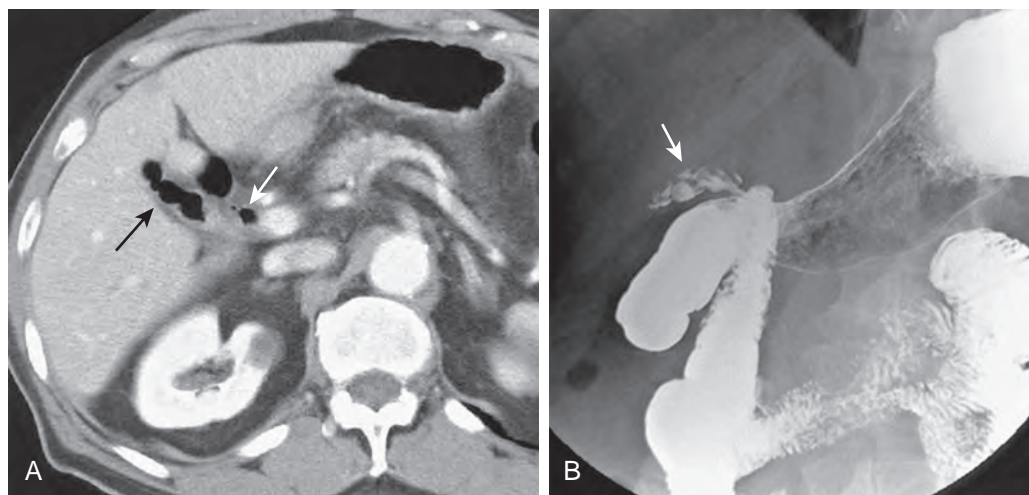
Cholecystoduodenal fistula secondary to chronic cholecystitis. A. CT demonstrates contracted gallbladder containing air (black arrow). There is also air in the CBD (white arrow). B. Upper gastrointestinal series demonstrates fistula between gallbladder and proximal duodenum (arrow).
